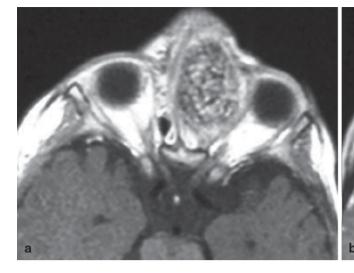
a MRI of a nasal chondromesenchymal hamartoma. Axial contrast-enhanced T1-weighted images revealed a heterogeneously enhancing mass in the left nasal cavity. b Axial T2-weighted MRI scan
